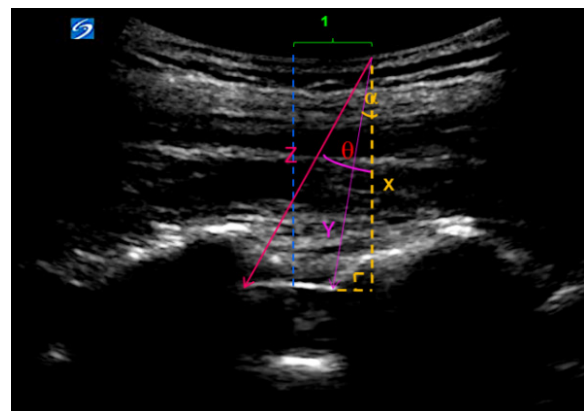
Paramedian sagittal oblique view (PSO view) of neuraxial ultrasound scanning.
